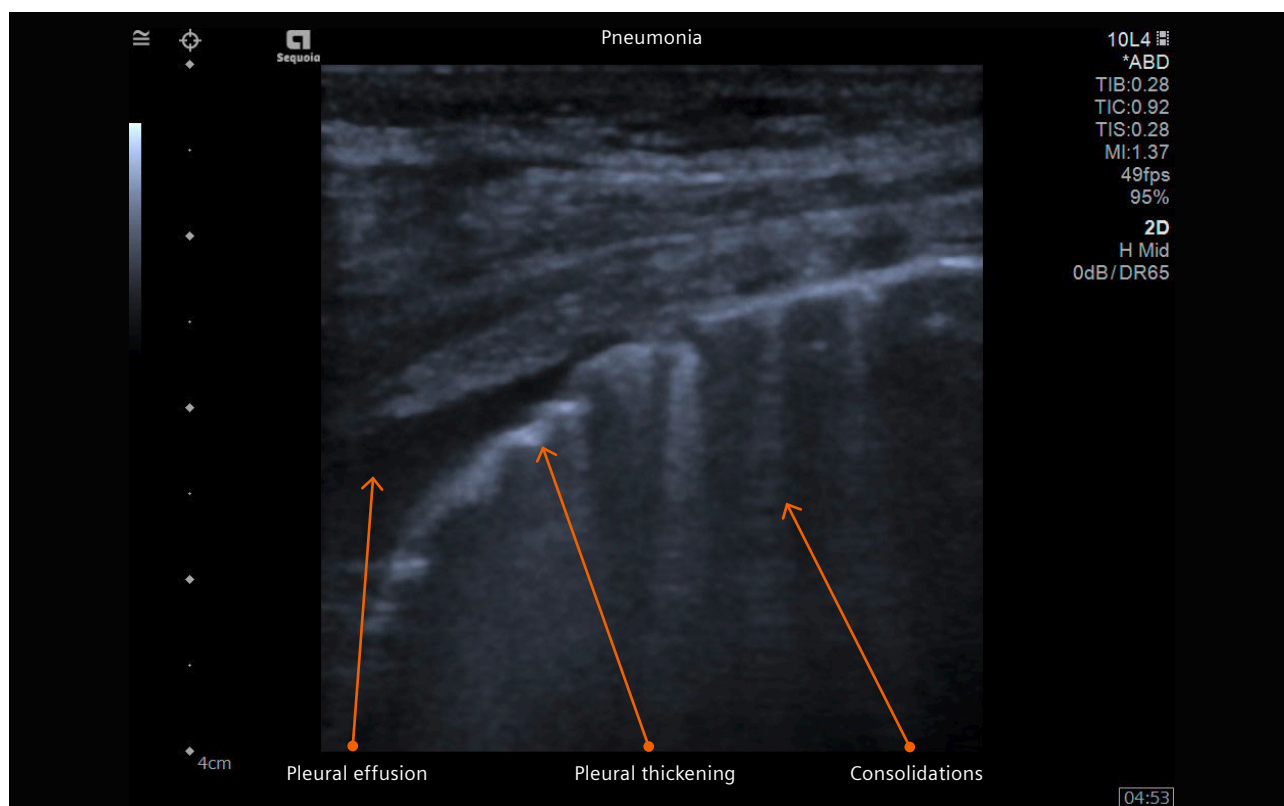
Pneumonia examination of the lung with a linear transducer. Ultrasound findings including pleural effusion, pleural thickening and consolidations with additional accompanying B-line artifacts are seen.
